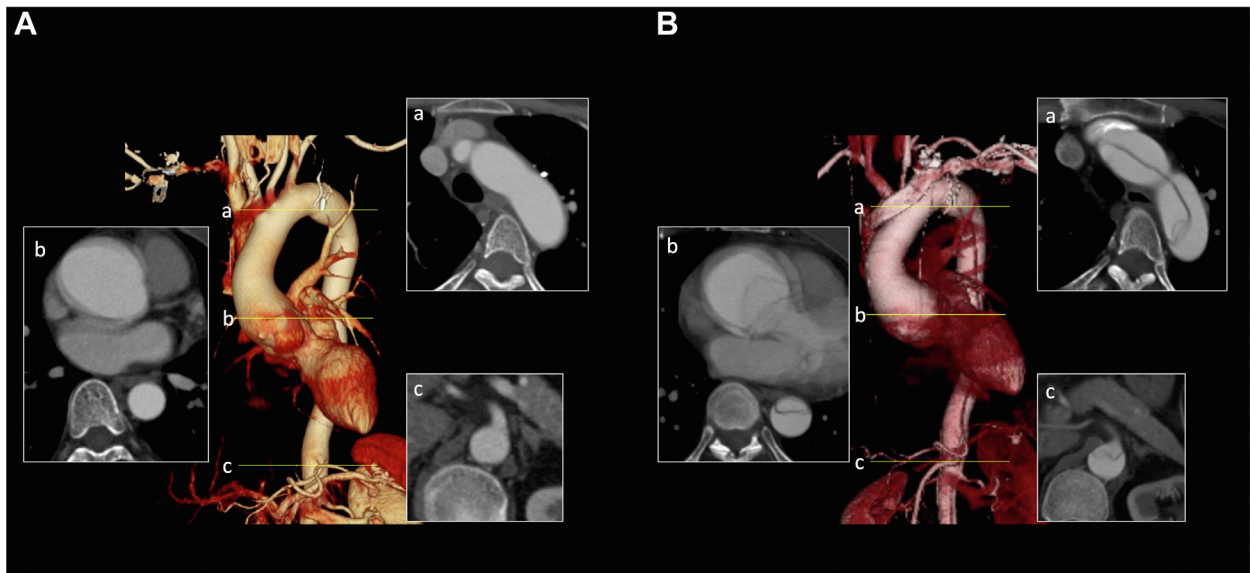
Enhanced CT Scans Before and After Dissection in Patient III-3
